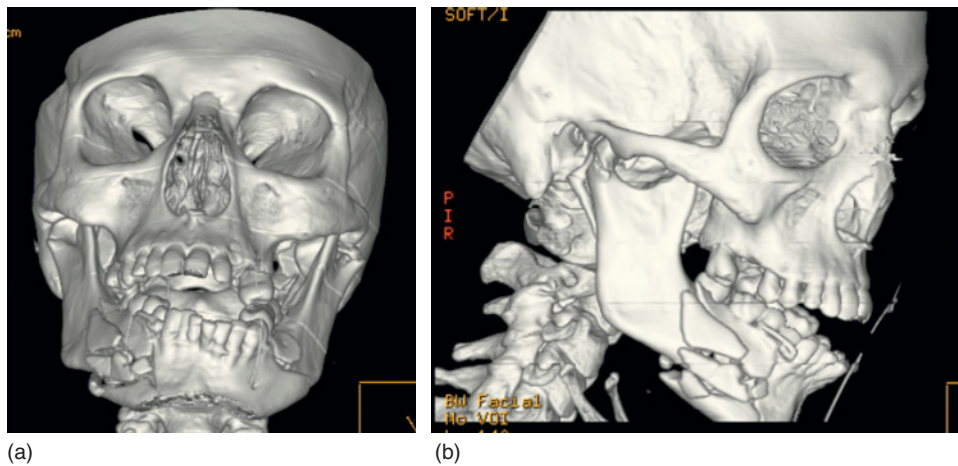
Three-dimensional computed tomography reconstruction showing multiple fractures of the mandible including a comminuted fracture of the right body. (Courtesy of Mr Andrew Cronin.)
